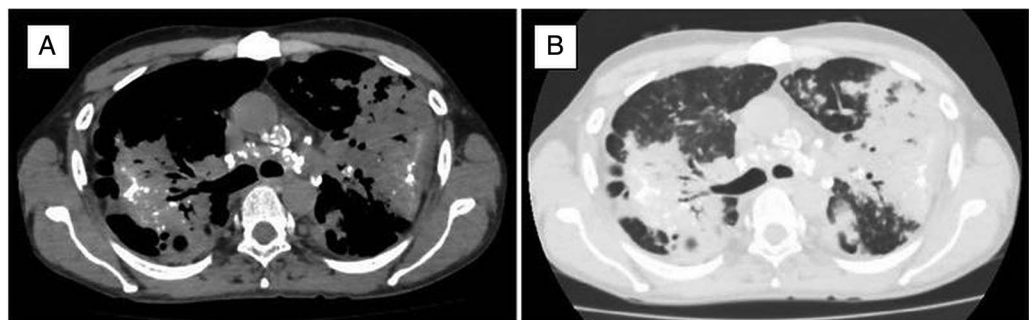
Non-contrast high-resolution CT of thorax showing (mediastinal window: A) eggshell calcification of lymph nodes and calcification within the masses; (lung window: B) large, symmetrical, bilateral conglomerate masses having irregular margins and nodular densities. The lateral interfaces of the mass lesions parallel the lateral chest wall.
